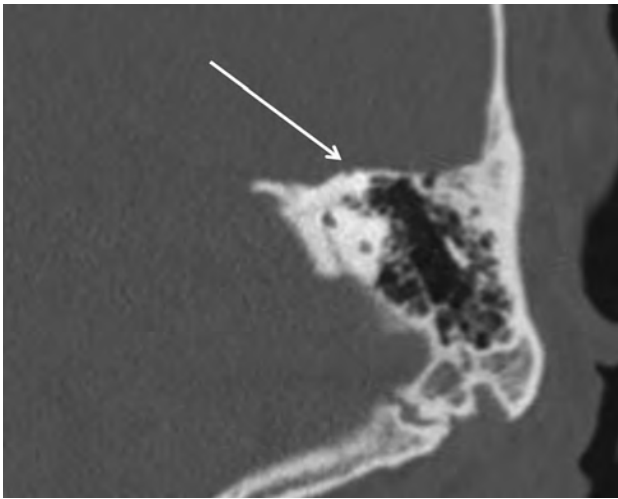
A thin-but-intact superior semicircular canal. Coronally reformatted CT of the temporal bone demonstrates very thin bone overlying the superior semicircular canal (*arrow*). This quantity of bone should be classified as intact in patients with and without suggestive symptoms.
